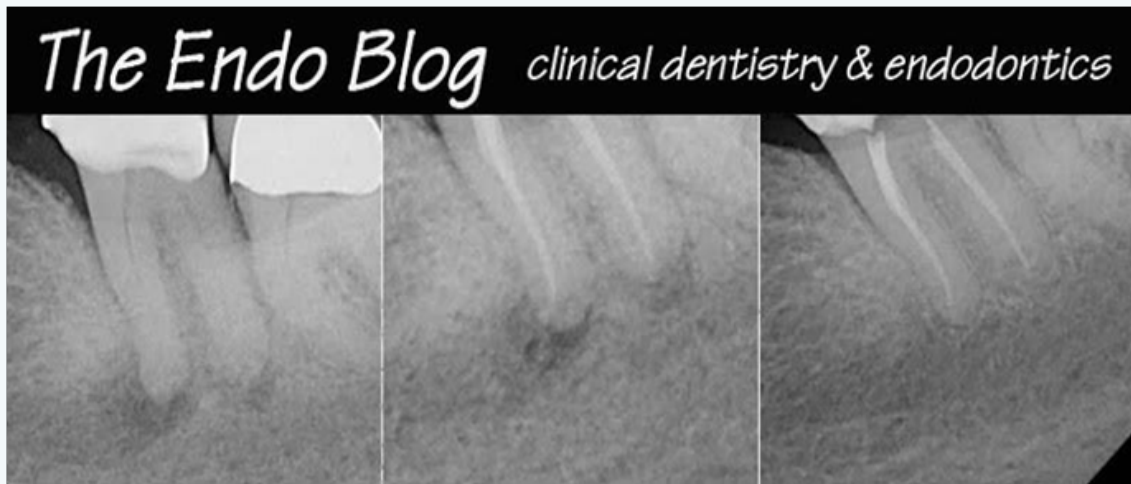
Periapical X-ray
